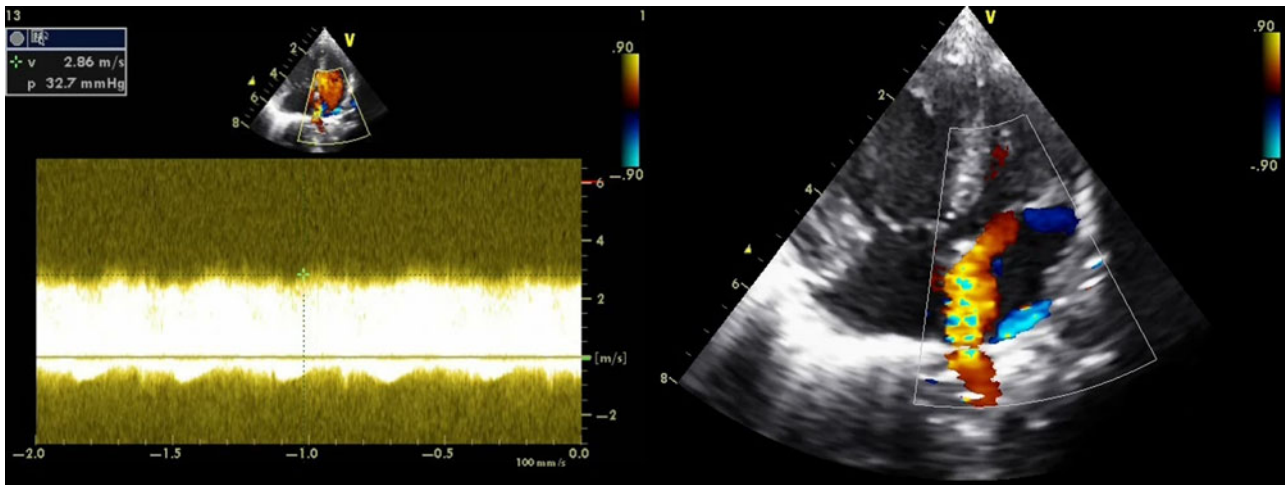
Continuous Doppler flow gradient in the common right pulmonary vein trunk.
